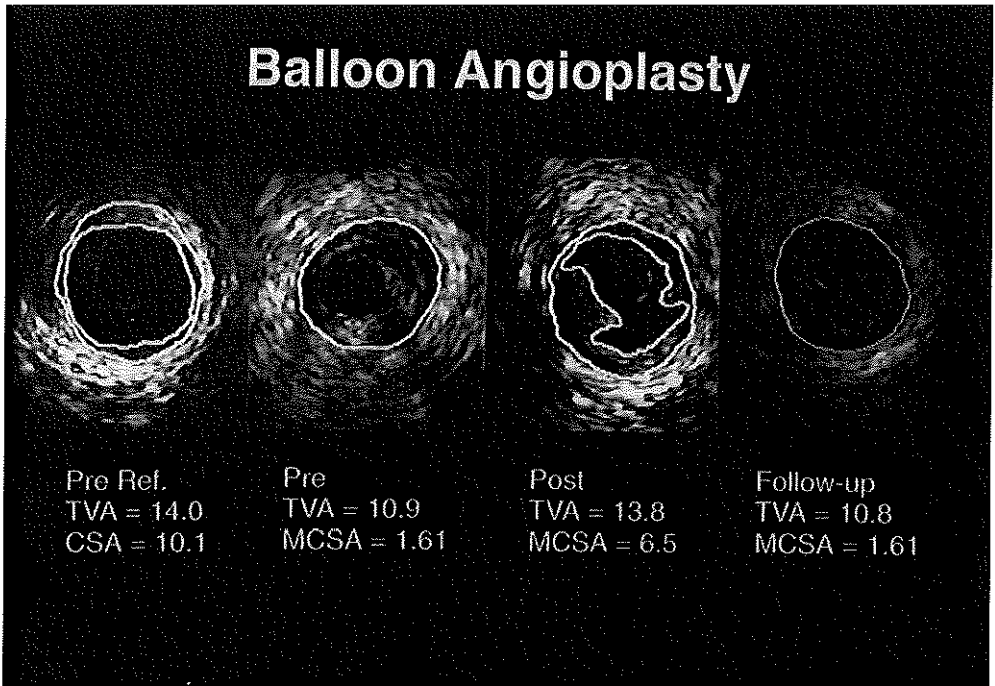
Intracoronary ultrasound (ICUS) images obtained from a patient with paradoxical shrinkage and treated with balloon angioplasty (BA). Reference segment showed total vessel area (TVA) was 14.0 mm² [extreme left panel]. Pre BA TVA was 10.9 mm² and minimal cross sectional area (MCSA) was 1.61mm² [middle left panel]. The ratio of the total vessel area (TVA) at MCSA divided by TVA at the reference site pre intervention (TVA ratio) was 0.78, hence the de novo remodeling mode was one of paradoxical shrinkage. Post BA MCSA improved to 6.5 mm² associated with TVA enlargement from 10.9 mm² to 13.8 mm² [middle right panel]. At follow-up MCSA decreased from 6.5 mm² to 1.61 mm² associated with TVA shrinkage from 13.8 mm² to 10.8 mm². In this case 39% of luminal loss was derived from intimal hyperplasia and 61% from late chronic recoil (vessel remodeling) [extreme right panel].
